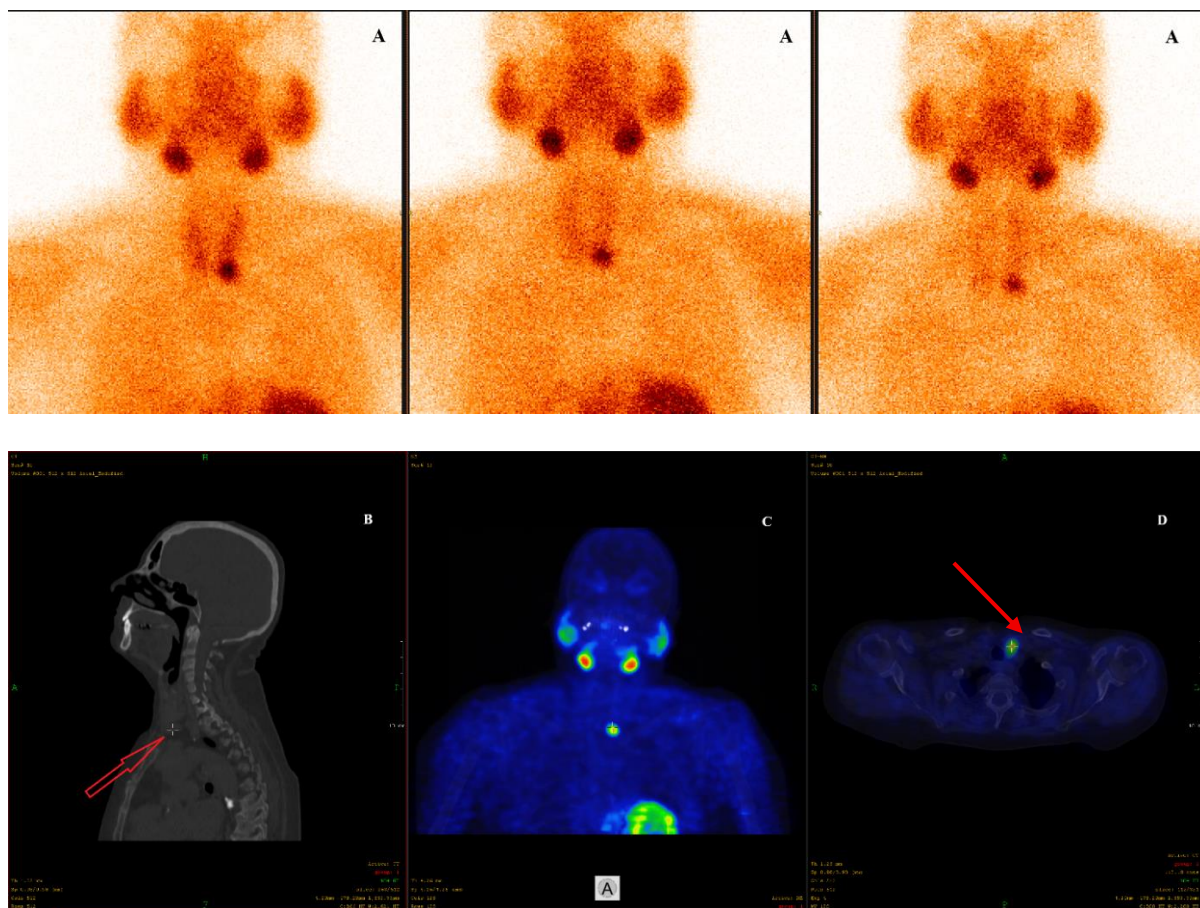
Combined planar and hybrid parathyroid imaging in the same patient. (A) Focal persistent radiopharmaceutical uptake in the lower neck/upper mediastinal region. A sagittal section of the CT scan (B) of the neck and thorax provides anatomy of the organs where the red arrow shows the lesion localization site. Image (C) shows only the fused coronal SPECT images and the localization of the lesion presented with high concentration of the radiopharmaceutical. (D) An axial SPECT/CT image showing exact localization of an ectopic parathyroid gland.
